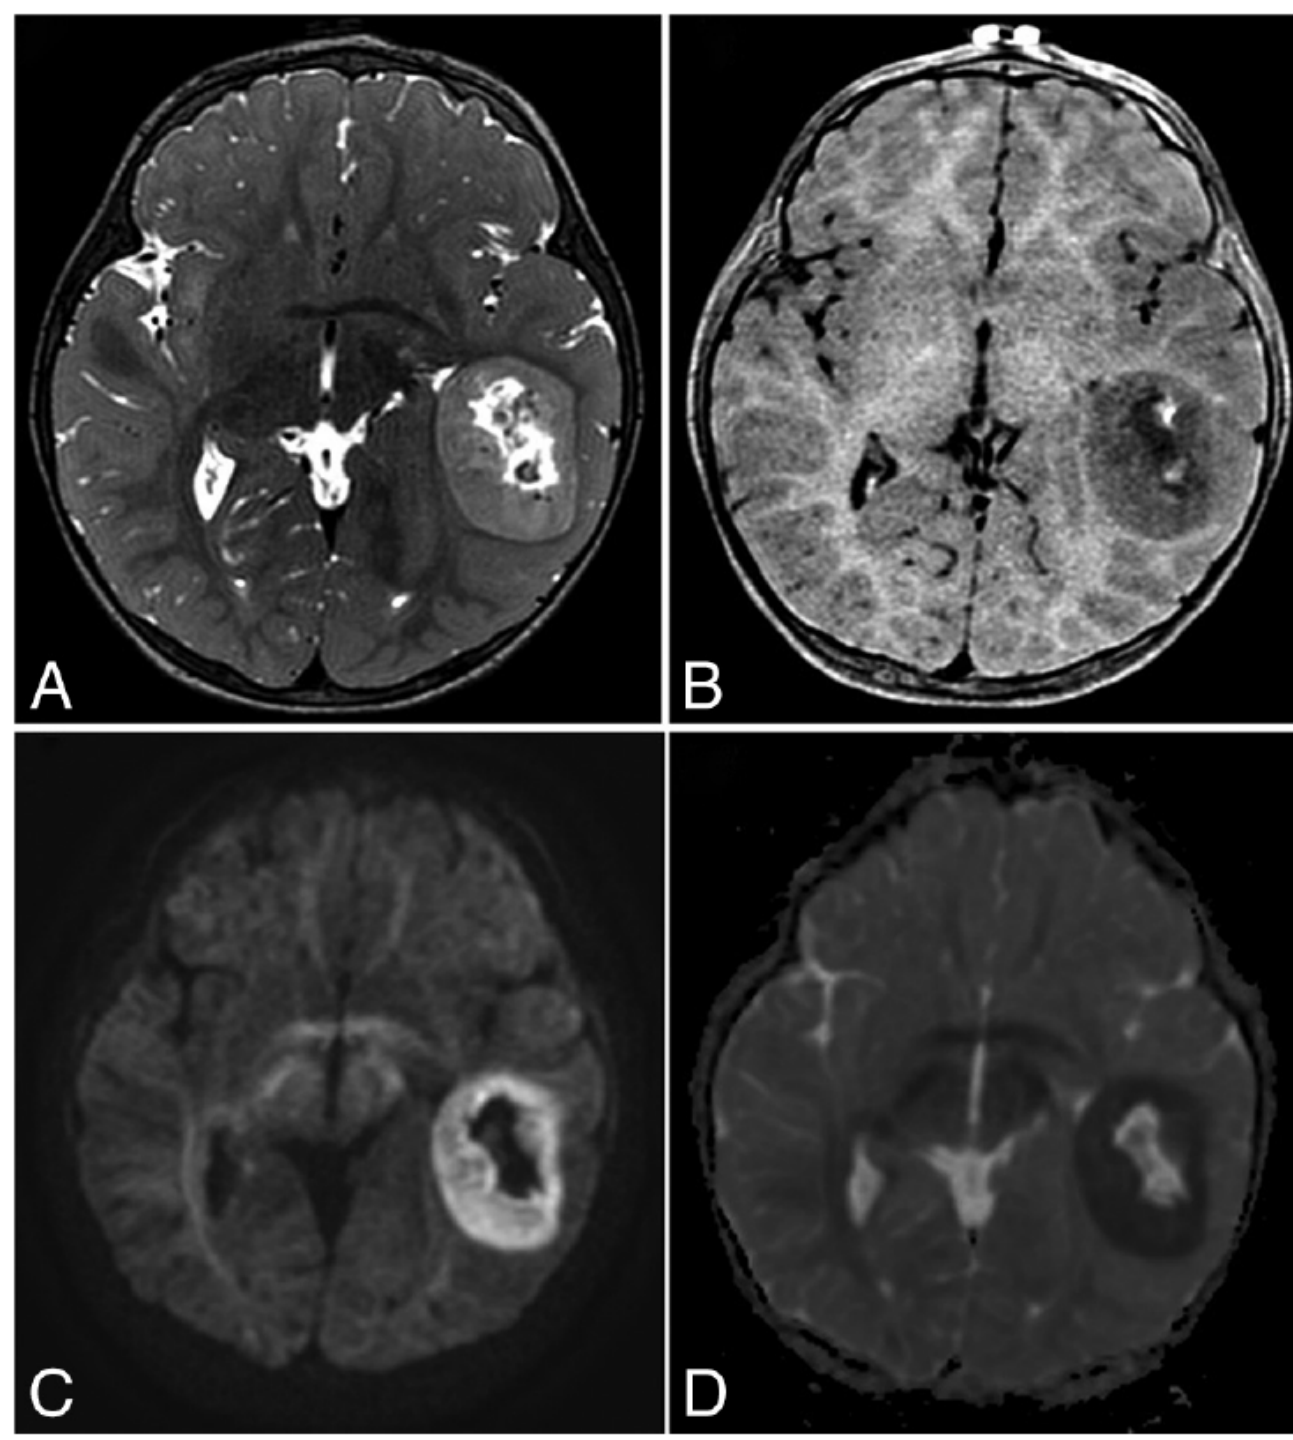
Characteristic MR imaging features of CNS tumors with a *BCOR* ITD. *A*, Axial T2-weighted image shows a well-defined mass, central necrosis, and no surrounding edema. *B*, Axial contrast-enhanced T1-weighted image shows poor enhancement after contrast medium administration. Axial DWI (*C*) and ADC map (*D*) show restricted diffusion of the solid portions of the tumor.
